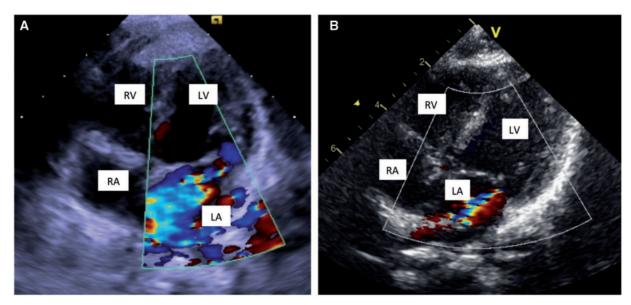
Transthoracic echocardiographic 4-chamber view showing mitral regurgitation. (A) Case 1 mitral insufficiency 4 of 4 and (B) Case 2 mitral insufficiency 2 of 4. RA: right atria; LA: left atria; RV: right ventricular; LV: left ventricular.
